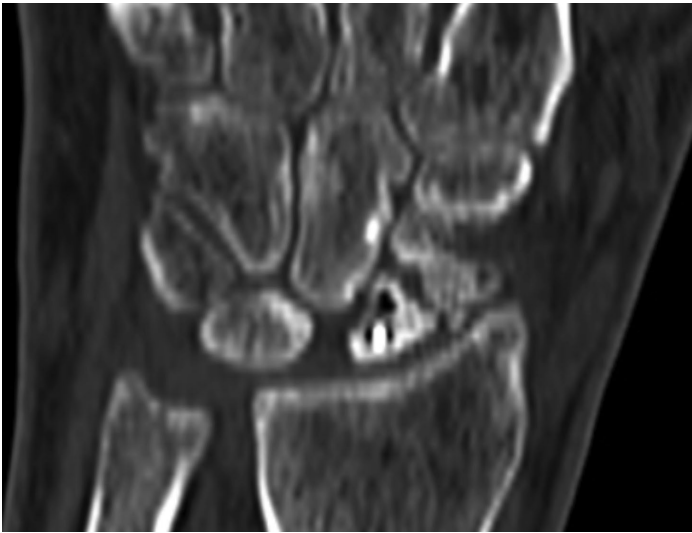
CT R wrist five months status post right scaphoid nonunion repair with distal radius bone graft and plate and screw fixation demonstrating no evidence of bony bridging or incorporation of bone graft.
